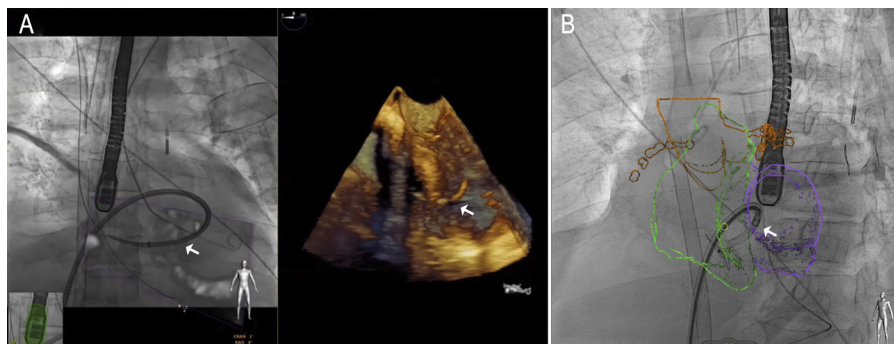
Example of fusion imaging with echocardiography (A) and computed tomography (B) during percutaneous occlusion of a postinfarction interventricular communication. Note the sheath passing through the defect.
